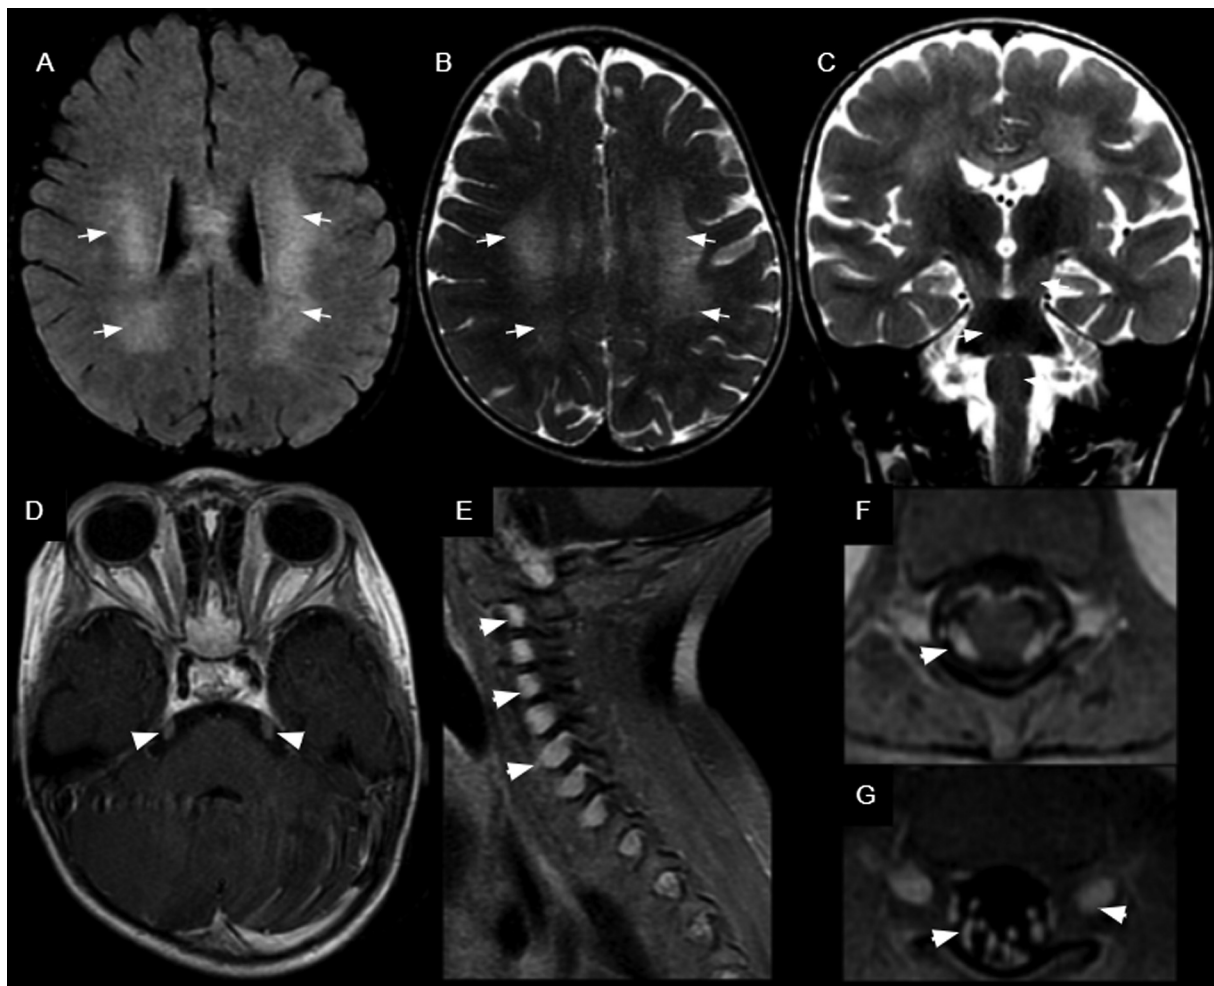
Brain MRI scans revealing bilateral and symmetrical T2 and fluid-attenuated inversion recovery (FLAIR) hyperintense lesions in the white matter of the cerebral hemispheres, predominantly in the parieto-occipital regions, displaying a tiger-like or leopard-skin pattern (white arrows in A and B). Involvement of the brainstem and corticospinal tracts (white arrows in C) was observed, along with thickening and enhancement of the trigeminal nerves (white arrowhead in D) and spinal roots (white arrowheads in E, F, and G).
